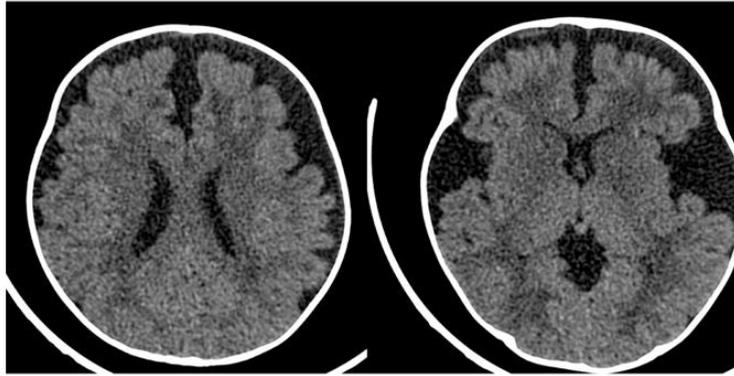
Axial non-contrast CT showing widening of the subarachnoid CSF spaces in the frontal lobes, and anterior to the sylvian fissures in the temporal lobes.
